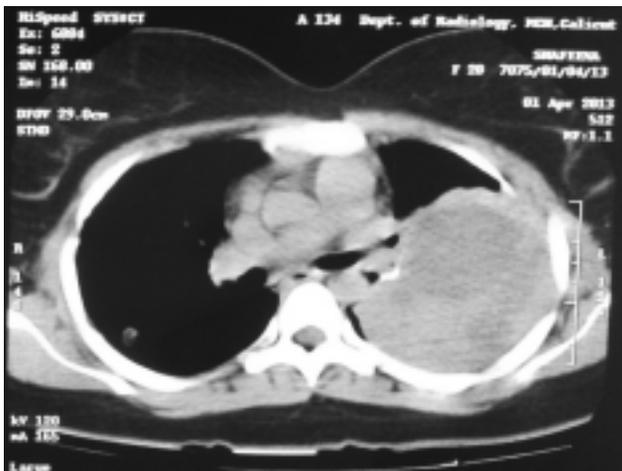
CT-Chest showing metastatic lesions of varying sizes
